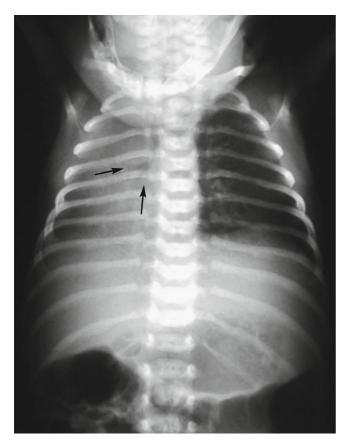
Chest X-ray of a neonate with agenesis of the right lung. *Black arrows* show the right lobar bronchi ending blindly. Mediastinum shifts to the right side
